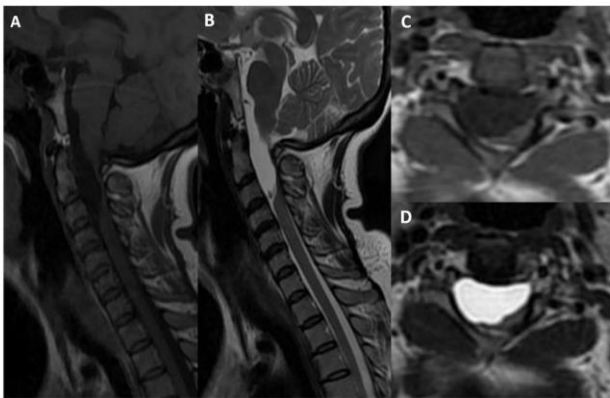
Sagittal T1 and T2 weighted (A, B) and axial T1 and T2W (C, D) MRI images demonstrating an Intradural arachnoid cyst (case 9) at C1 to C3 level with marked thinning of the cord.
